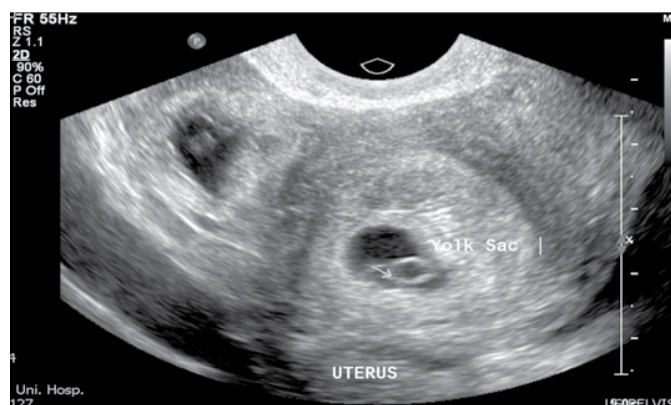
Sonogram showing the intrauterine pregnancy and concurrent adnexal pregnancy.
